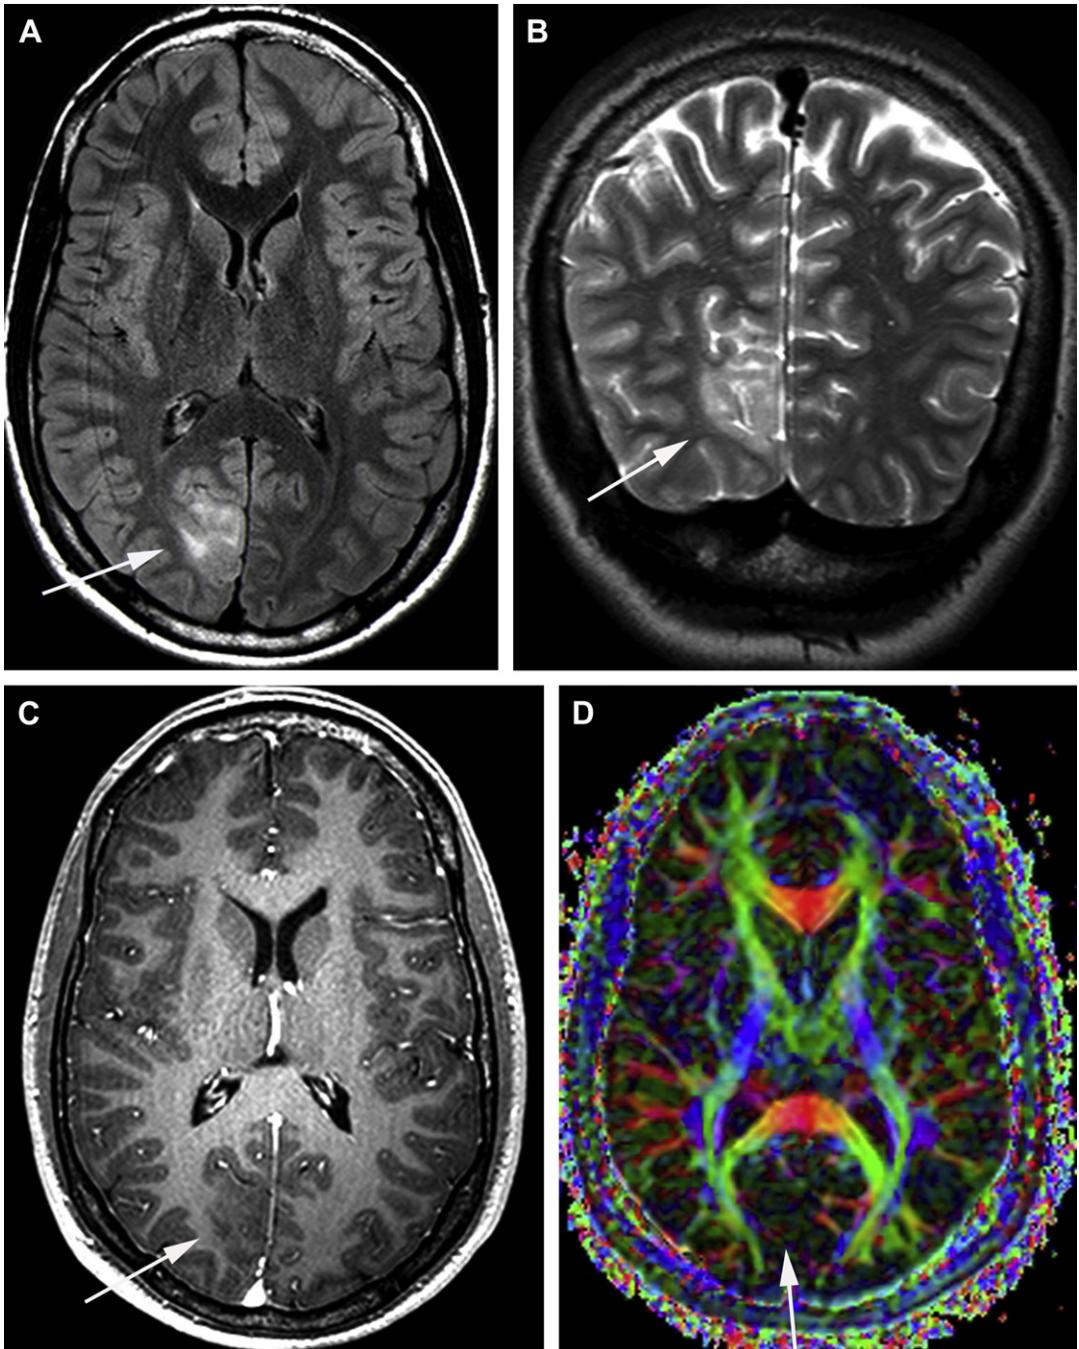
Right occipital FCD II. (A) Bright FLAIR signal in the white matter and cortex of the cuneus (*arrow*). (B) Similarly bright signal on T2TSE (*arrow*). (C) Low T1 signal of the white matter blurring the cortico-subcortical junction (*arrow*); no contrast enhancement. (D) Fractional anisotropy (FA) color map demonstrates a lack of transverse fascicular organization in the white matter of the cuneus (*arrow*).
